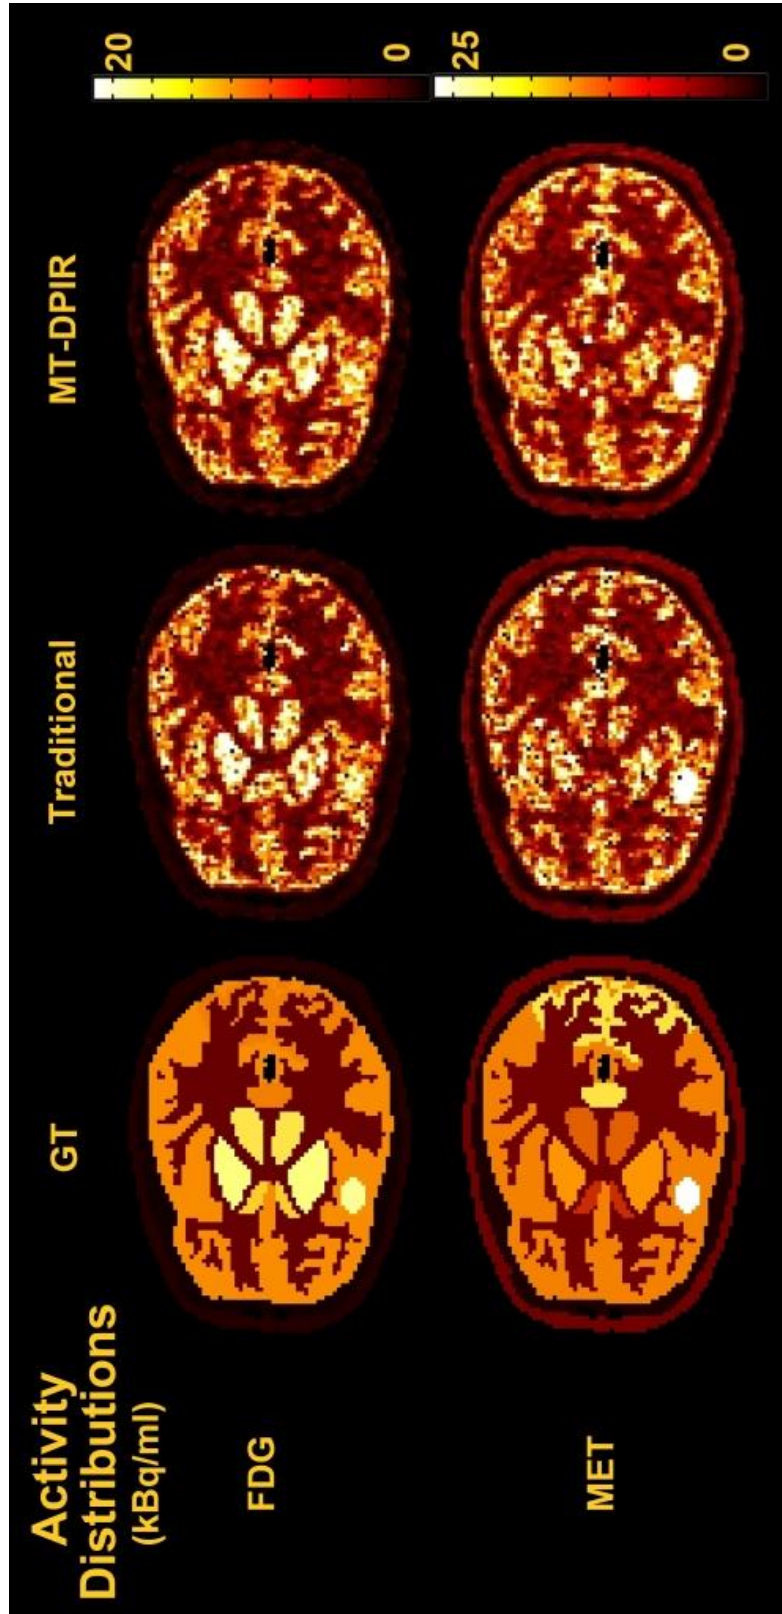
An exemplary frame ($t = 27.5$ min) of separated tracer activity distributions for FDG and MET respectively, reconstructed using the traditional method (192 iterations) and MT-DPIR (240 iterations)
